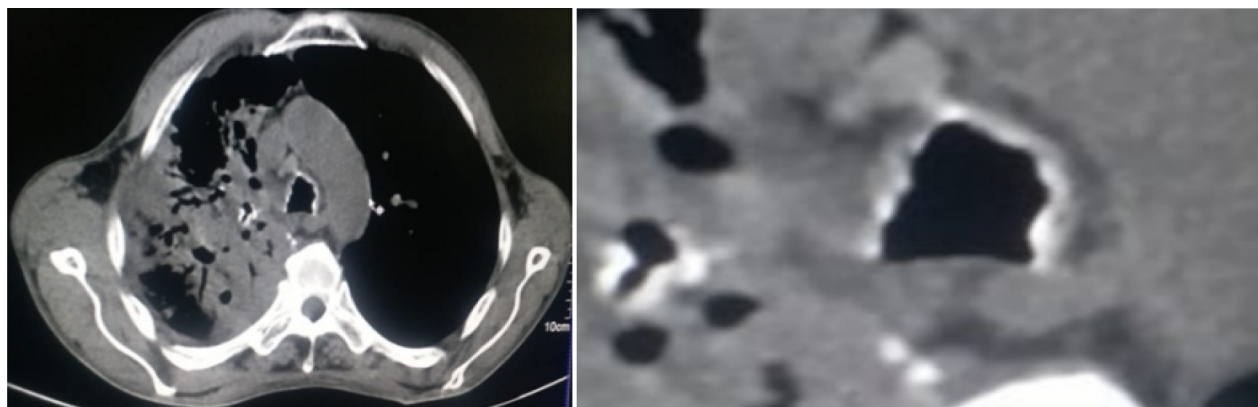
CT Chest showed consolidation with cavities in the right upper lobe, irregular thickening and nodularity of tracheal cartilage with calcification in the trachea and both main bronchi suggestive of Tracheobronchopathia osteochondroplastica
